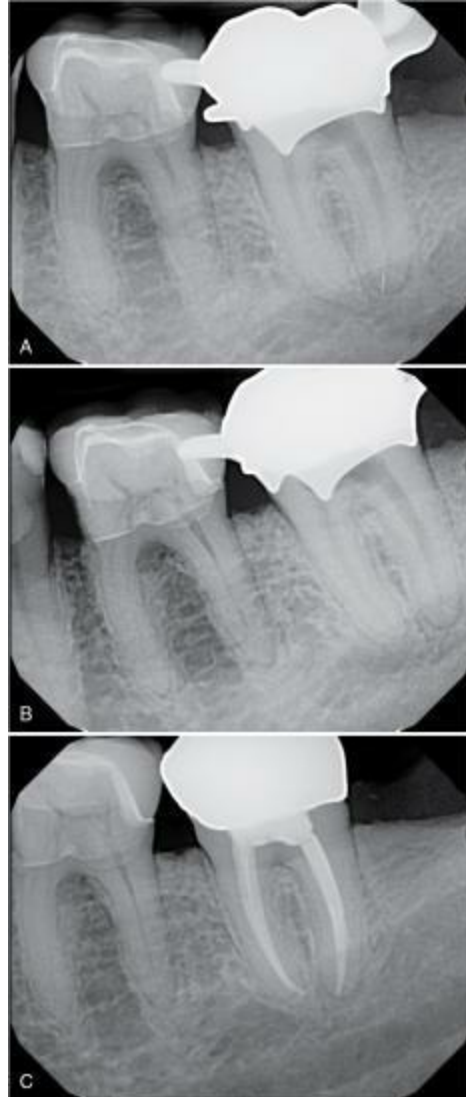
Separated file removal using the GentleWave System. A, A small fragment of file is lodged at the apical extent of the canal. B, After one irrigation cycle of the GentleWave device, a check radiograph shows that the separated instrument has been removed. C, Postobturation image.
